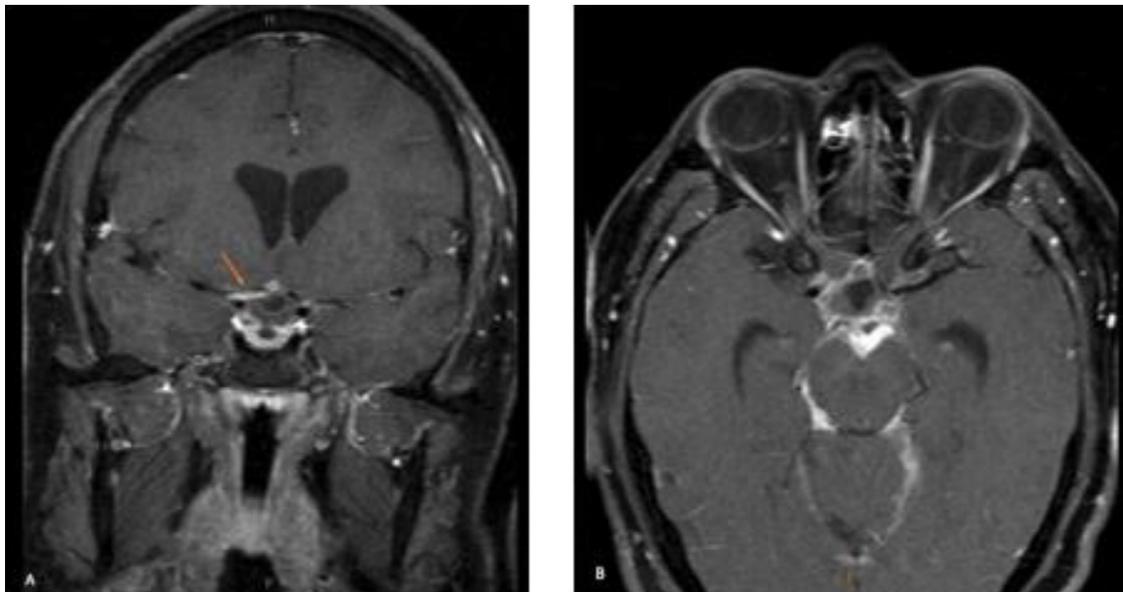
Case 1. (A) Postcontrast coronal T₁-weighted magnetic resonance image with abnormal enhancement around the right optic nerve near the optic chiasm (arrow). (B) Postcontrast axial image depicting leptomeningeal enhancement and edematous changes in the surrounding midbrain area.
